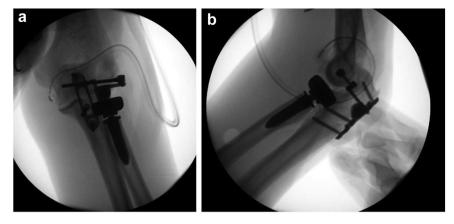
Intraoperative fluoroscopic IJS evaluation. The intraoperative fluoroscopic images show the final radiographic evaluation of IJS implantation in (a) an anteroposterior view and (b) lateral view. IJS, internal joint stabilizer.
